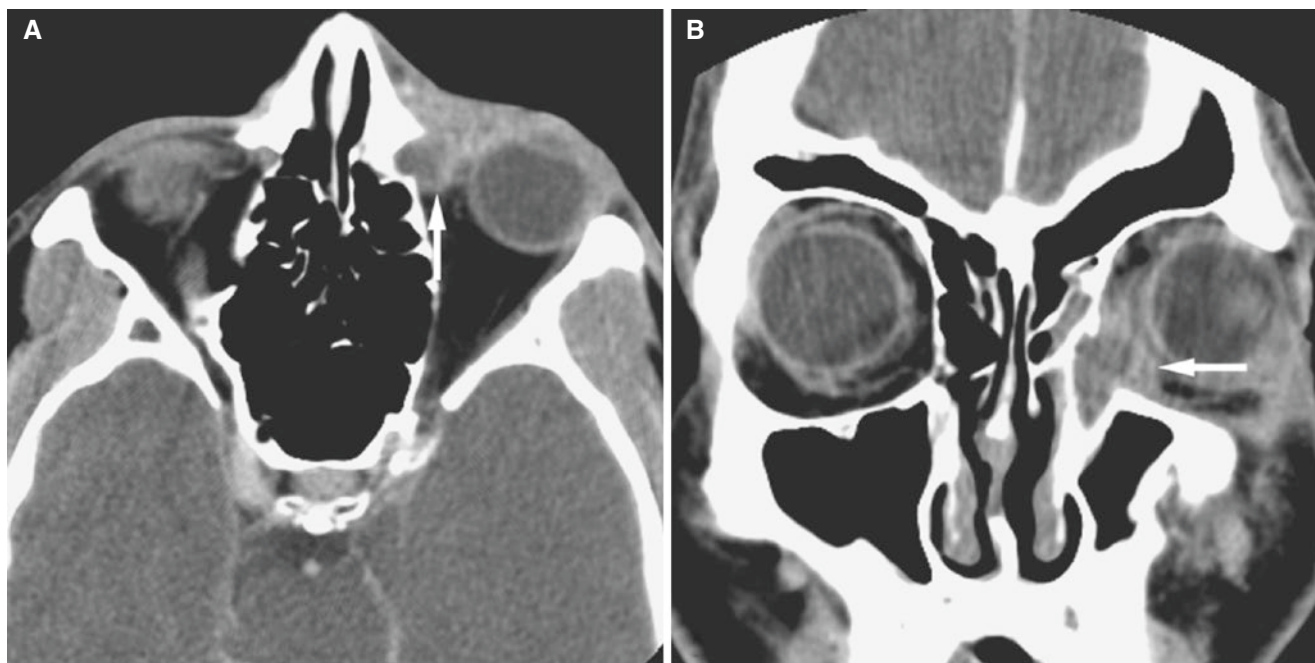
Dacryocystocele; 43-year-old female with periorbital recurrent swelling. Axial (A) and coronal (B) post-contrast CT images show left periorbital soft-tissue swelling representing orbital cellulitis.
